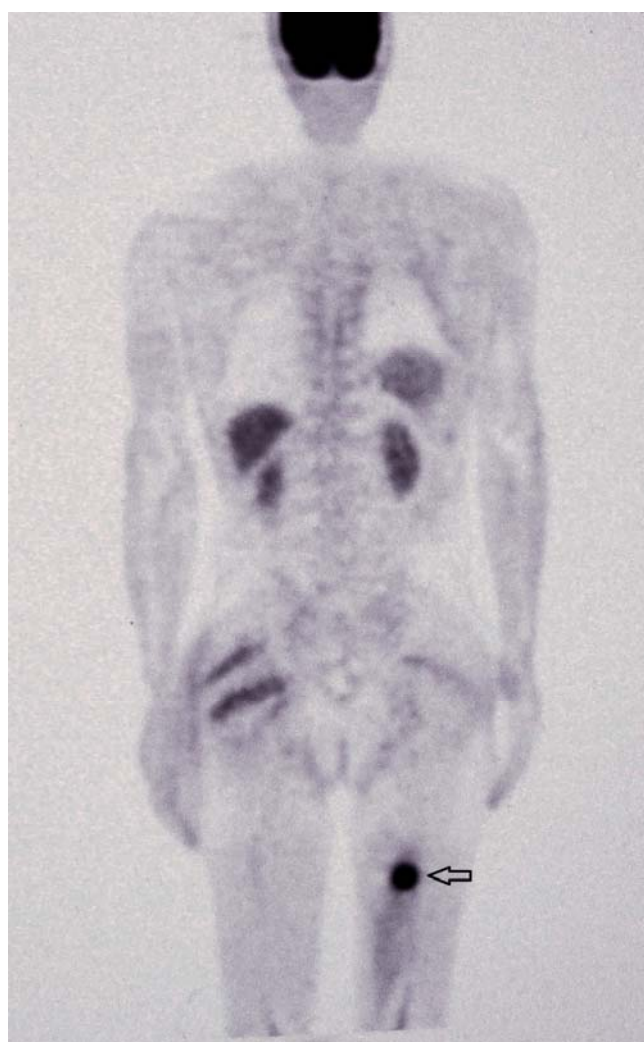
PET-CT revealed an isolated metastasis with a 9.5 SUV max value at the back of the left thigh region.
